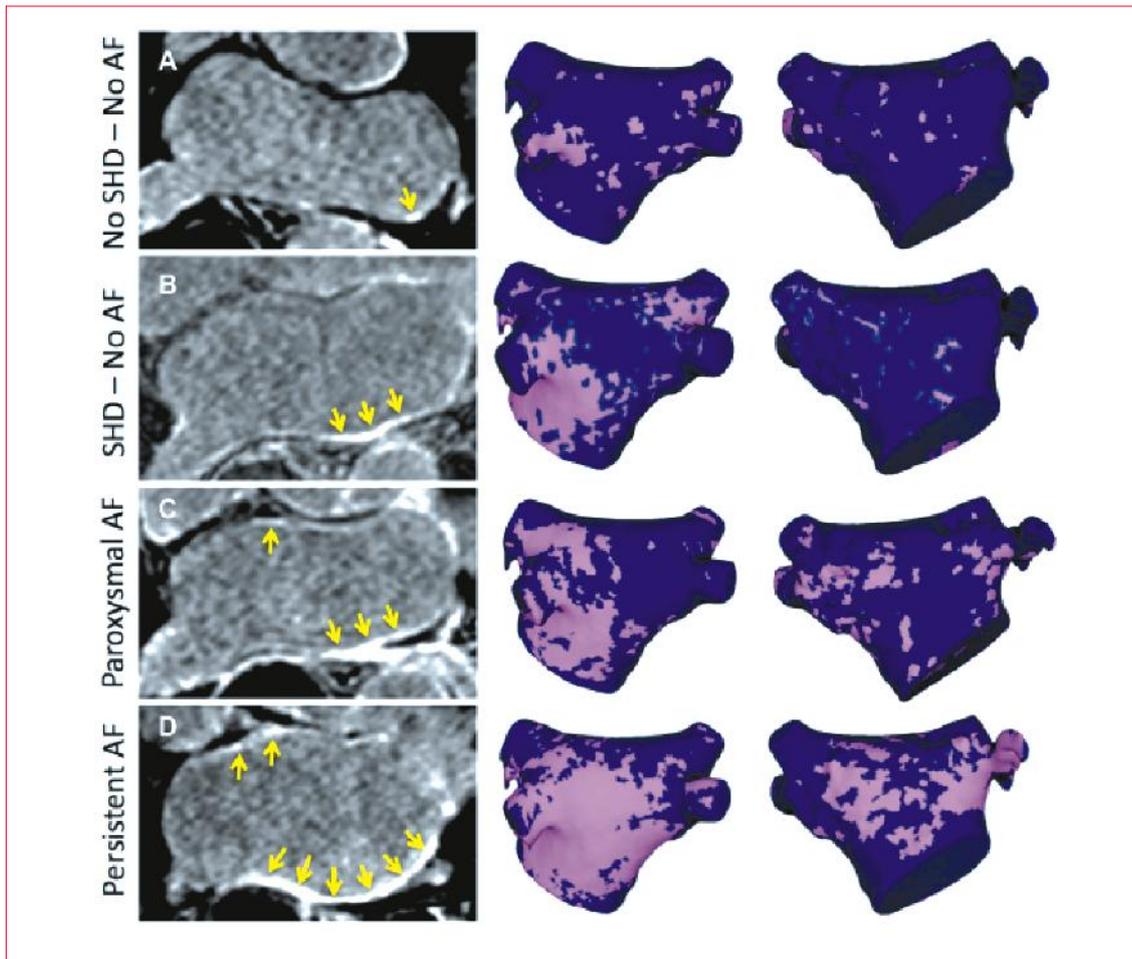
Delayed Enhancement MRI images and corresponding registered DE maps in 4 patients with different clinical characteristics. 1st Column represents raw delayed-enhancement images from patients with no structural heart disease and no AF (A), structural heart disease and no AF (B), paroxysmal AF (C), and persistent AF (D). Columns 2 and 3 represent posterior and anterior segmented DE maps registered on template. Yellow arrows indicate enhanced areas. DE: atrial delayed enhancement; SHD: structural heart disease; AF: atrial fibrillation. Reproduced with permission from (15)
